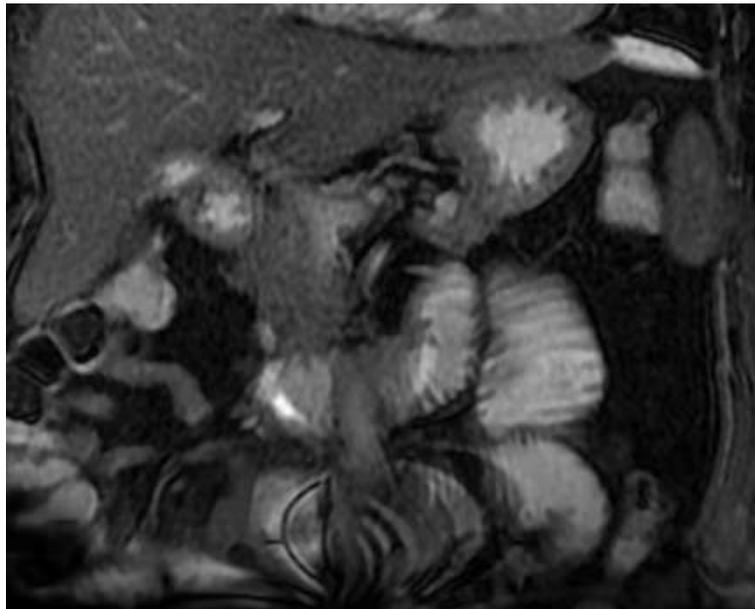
Postoperative MRI of the abdomen demonstrating a 1.6 x 1.4 cm duodenal diverticulum
